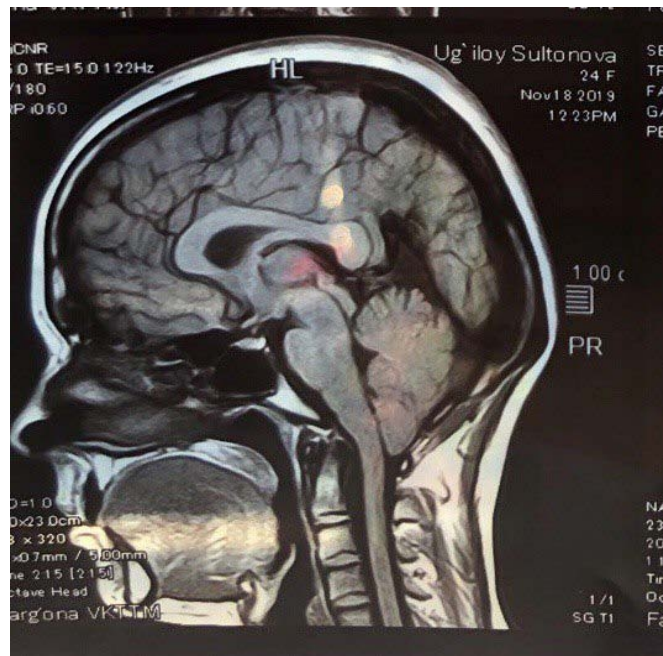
An example of MRI of patient S., with Chiari malformation of type 1 with ectopia of cerebellar tonsils 14mm on the right and 12mm on the left
